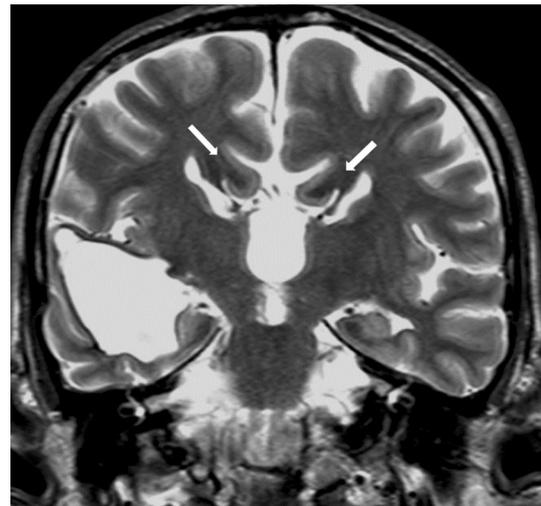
Brain MRI. Coronal slice. T2-weighted sequence. Presence of bilateral Probst bundle (arrows). Right temporal ischemic stroke
